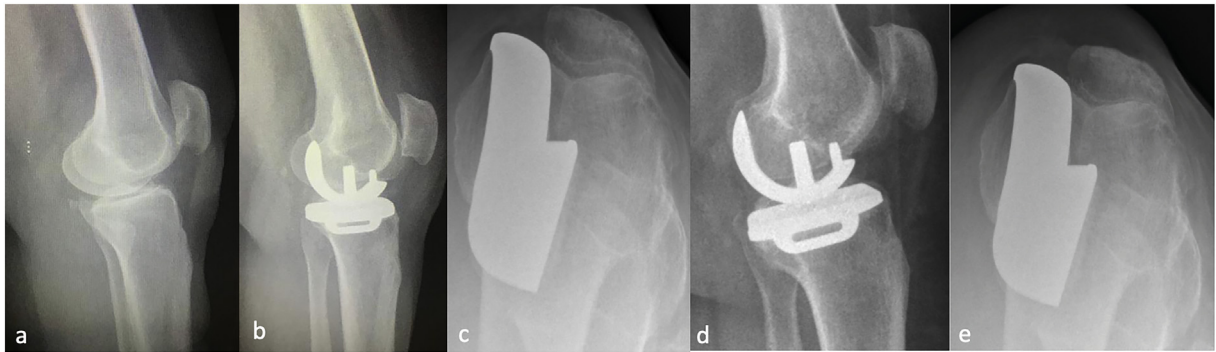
Patellofemoral compartment osteoarthritis progression in a 56-year-old patient. (a) Preoperative, (b, c) postoperative one-year, (d, e) postoperative five-year follow-up radiographs.
